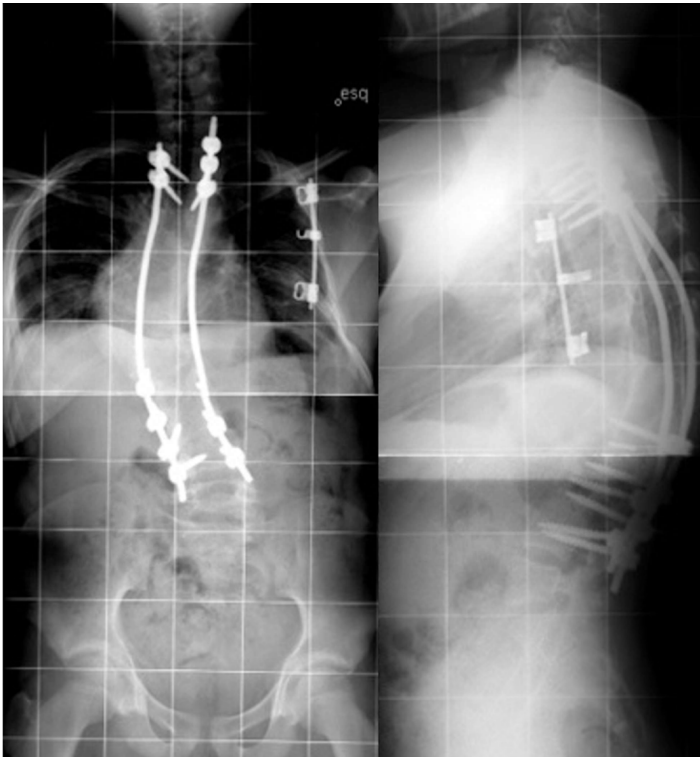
Case 1 - AP and lateral X-Ray views of the spine after posterior fusion.
